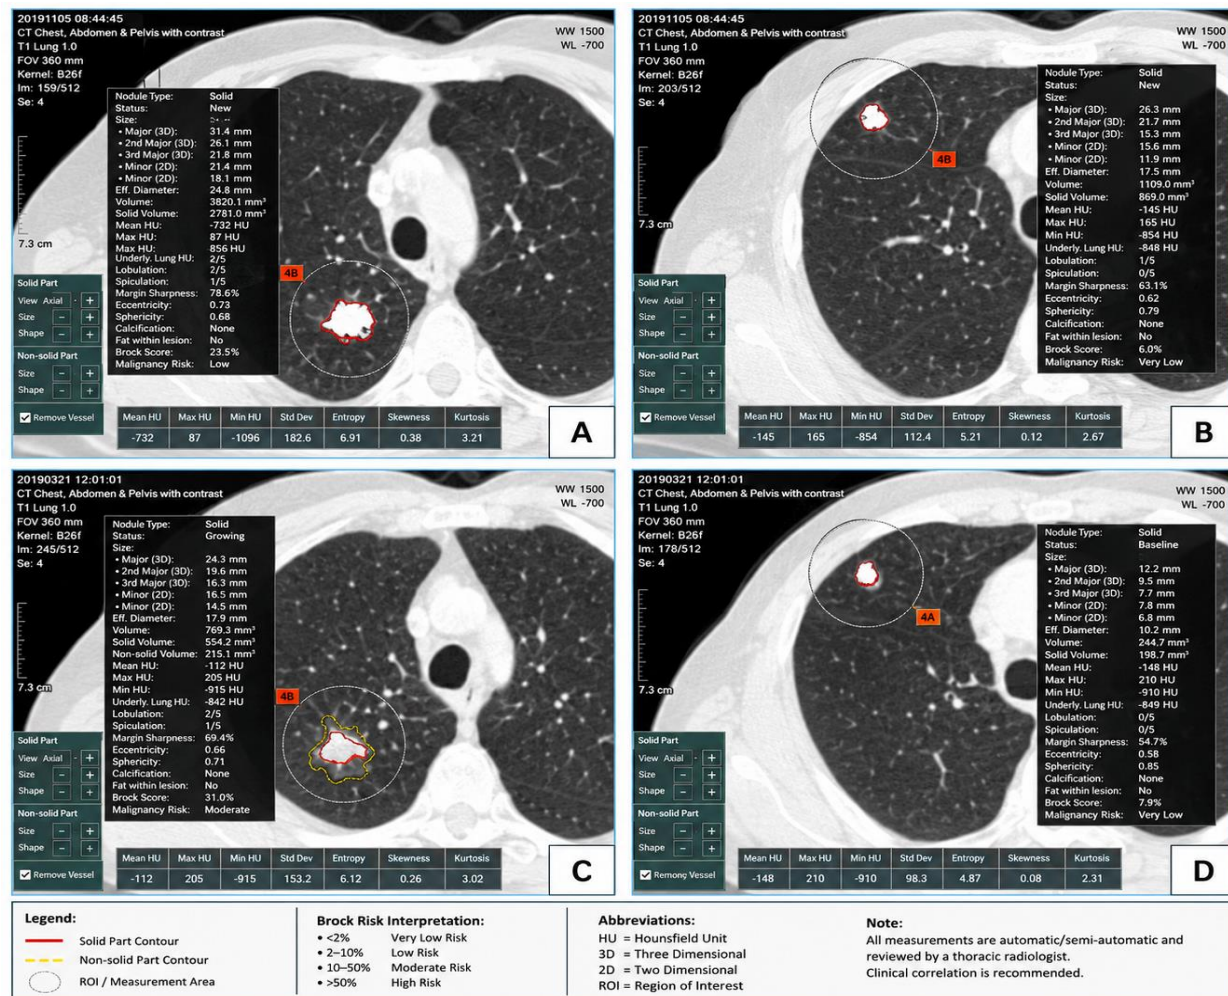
Automated pulmonary nodule analysis on chest CT images with morphological measurements and malignancy prediction.
